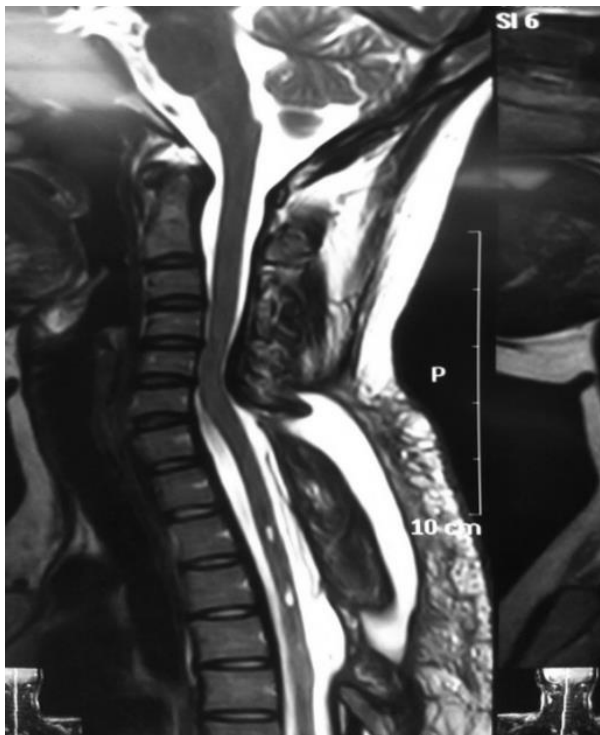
MRI Cervico-dorsal Spine sagittal preoperative (A) T1 image- A hyperintense intradural extramedullary lesion present at C7-D4, compressing the spinal cord. (B) T2 image- A hypointense intradural extramedullary lesion present at C7-D4, compressing the spinal cord.
